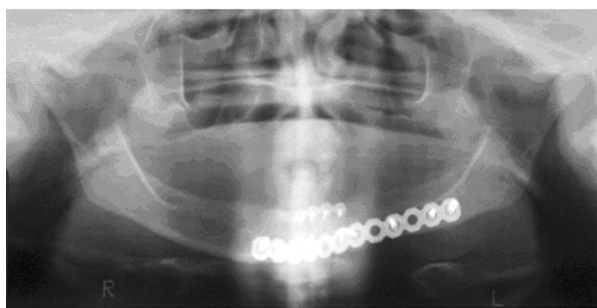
Case 3. Panoramic radiograph showing bone healing 12 months after reconstruction of the bone defect with rhBMP-2 combined with autogenous bone marrow aspirate and allogenic bone chips.
